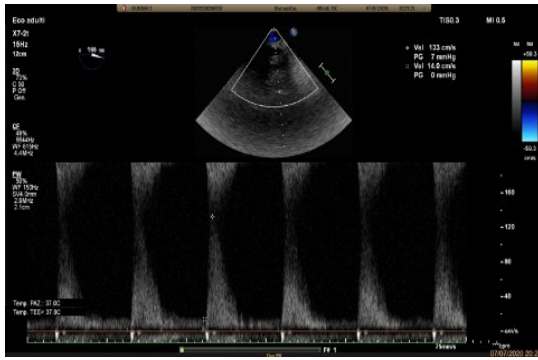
Trans-esophageal pulse Doppler of the celiac trunk after induction of general anesthesia.
